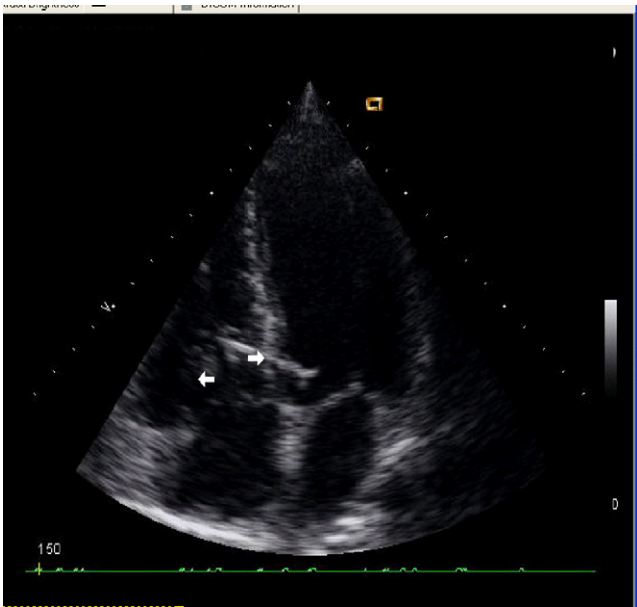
Transthoracic echocardiography showing needle (left arrow) and vegetation (right arrow).
